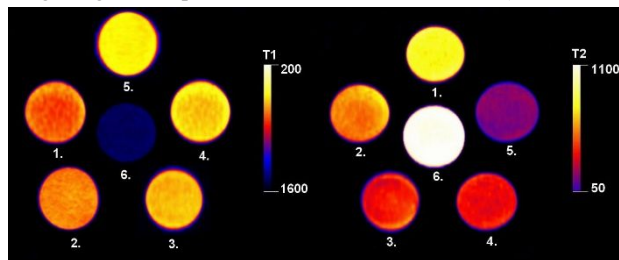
Representative T_1 - (left) and T_2 - weighted (right) MRI images (3 T) of the $[\text{Mn}(\text{PC2A-EA})]$ complex in human serum (Seronorm) at different pH values (pH=7.50 (1), 7.25 (2), 7.08 (3), 6.81 (4) and 6.67 (5), $c_{[\text{Mn}(\text{PC2A-EA})]} = 1 \text{ mM}$). The T_1 relaxation times of the samples are: 298 ± 2 (1), 257 ± 2 (2), 232 ± 2 (3), 233 ± 2 (4), 222 ± 2 (5) ms, while the T_2 data are as follows 456 ± 52 (1), 200 ± 11 (2), 144 ± 6 (3), 125 ± 5 (4) and 113 ± 4 (5) ms
